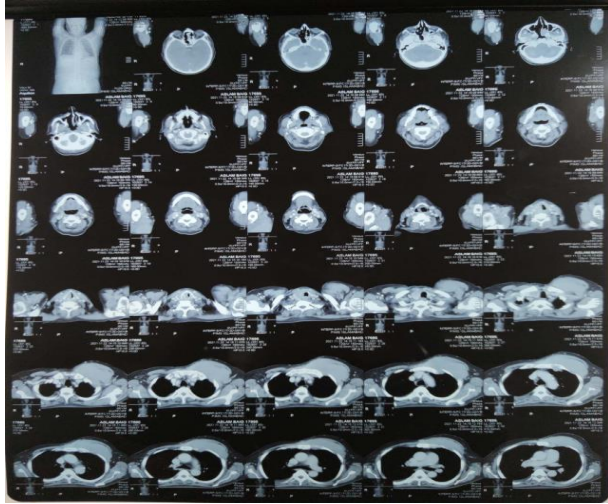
CT Scan Chest with contrast
